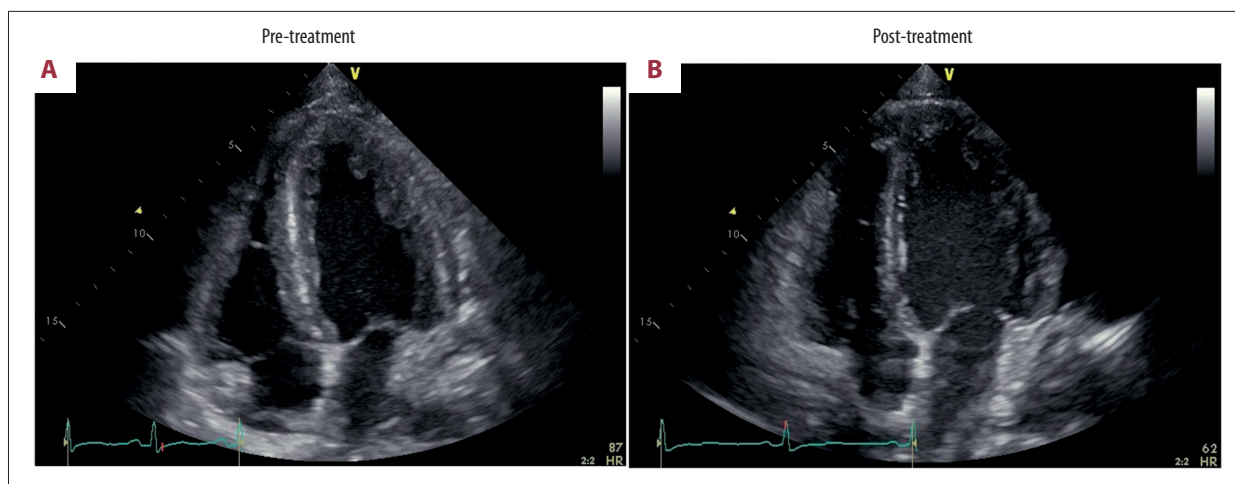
Four-chamber echocardiograms in a 33-year-old Japanese man who presented with drug reaction with eosinophilia and systemic symptoms (DRESS) and myocarditis, taken on hospital admission, and 11 days following treatment with corticosteroids. (A) End-diastolic, apical four-chamber echocardiogram on admission. The cardiac wall thickness, narrowing of the internal lumen, and pericardial effusion are shown. (B) End-diastolic, apical four-chamber echocardiogram 11 days following treatment with corticosteroids. The cardiac abnormalities shown in A have resolved.
